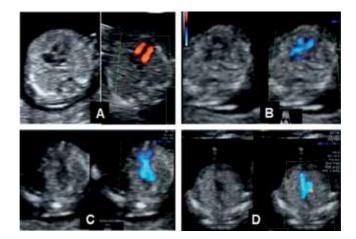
FT cardiac sweep of a normal heart, duplex mode. (A): 4CV plane: gray-scale imaging shows, crux cordis and pulmonary veins entering left atrium; color Doppler imaging shows equal atrioventricular flow and no flow between ventricles. (B): LVOT plane with the aortic emergence, septoaortic continuity and aortic flow. (C): Crossing of the great vessels. (D): 3VT plane – the confluence of arterial arches on left of spine with normal direction and equal flow.
